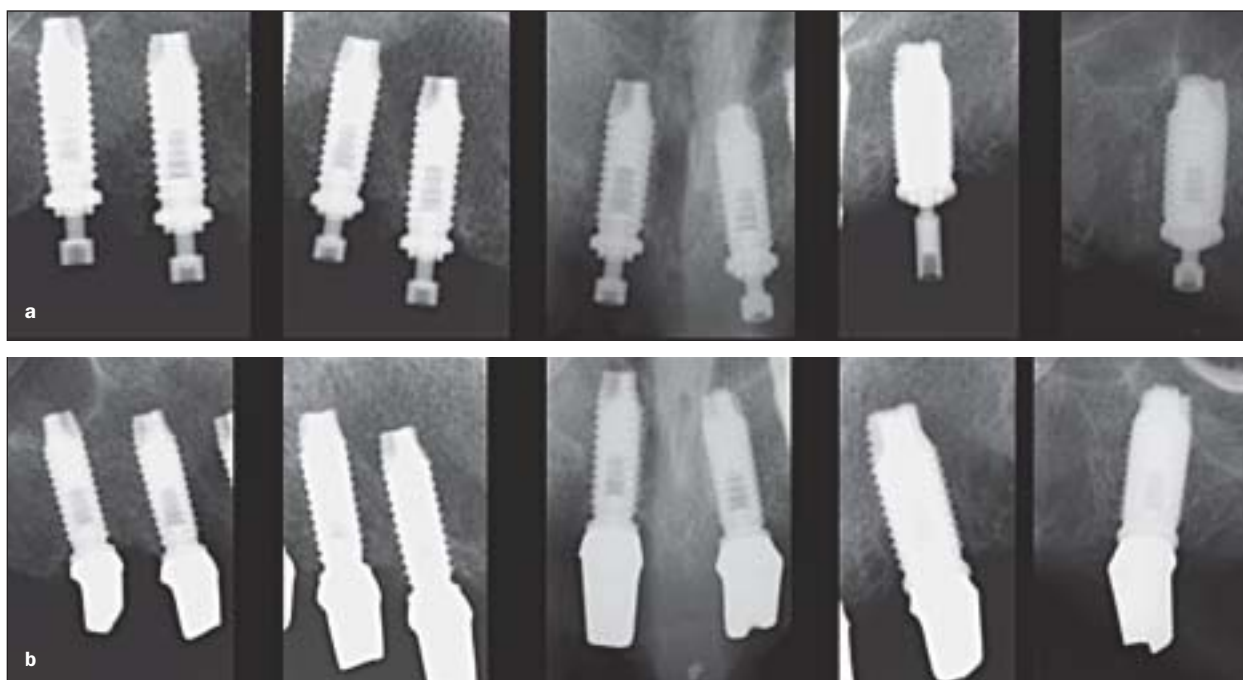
Radiographs of the patient (a) before tooth extraction and after implant placement and (b) at the 18-month follow-up examination.
